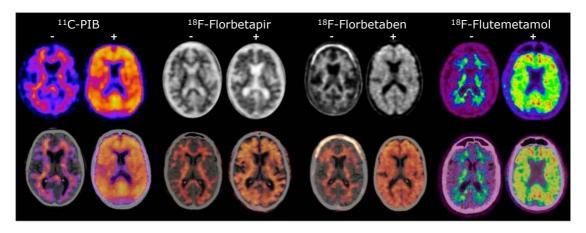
Representative amyloid axial PET images obtained using the three approved amyloid PET radiopharmaceuticals. Top row; PET images, bottom row; PET/CT images. Amyloid negative (-), amyloid-positive (+). Abbreviations: PET, positron emission tomography; CT, computed tomography. From (72).
